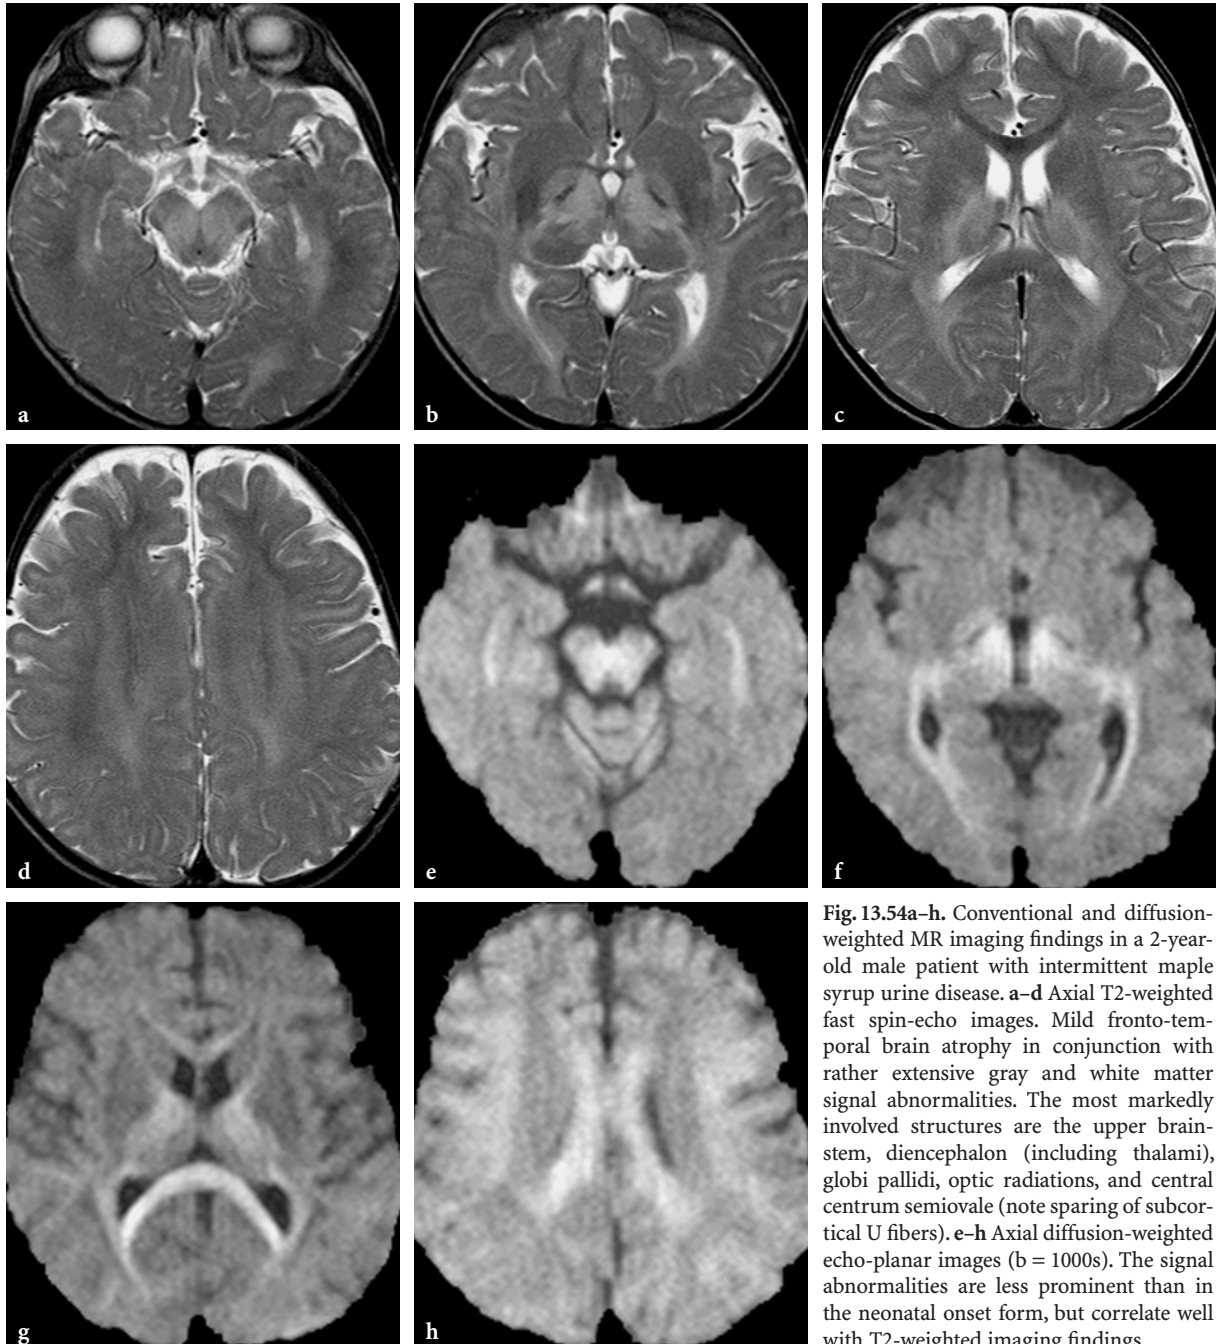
Conventional and diffusion-weighted MR imaging findings in a 2-year-old male patient with intermittent maple syrup urine disease. a–d Axial T2-weighted fast spin-echo images. Mild fronto-temporal brain atrophy in conjunction with rather extensive gray and white matter signal abnormalities. The most markedly involved structures are the upper brainstem, diencephalon (including thalami), globi pallidi, optic radiations, and central centrum semiovale (note sparing of subcortical U fibers). e–h Axial diffusion-weighted echo-planar images ($b = 1000s$). The signal abnormalities are less prominent than in the neonatal onset form, but correlate well with T2-weighted imaging findings
